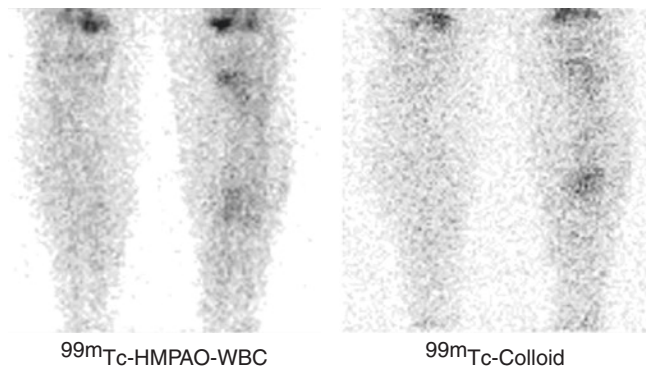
Evaluation of a patient with suspected osteomyelitis of left tibia, to rule out the presence of acute infection. Left panel: ^{99m}Tc -HMPAO-WBC scintigraphy (planar image), showing mild accumulation of labeled leukocytes in proximal and middle portion of diaphysis of left tibia, suggesting the presence of inflammation without infection. Right panel: scintigraphy with ^{99m}Tc -nanocolloidal albumin, showing uptake at the same site of ^{99m}Tc -HMPAO-WBC accumulation. The overall scintigraphic pattern confirms the presence of normally functioning bone marrow, thus ruling out the presence of acute infection (modified from: Lazzeri E. *Nuclear medicine imaging of bone and joint infection*. In: Lazzeri E, Signore A, Erba PA, Prandini N, Versari A, D'Errico G, Mariani G, Eds. *Radionuclide Imaging of Infection and Inflammation – A Pictorial Case-Based Atlas*. Milan: Springer; 2013:39–80)
